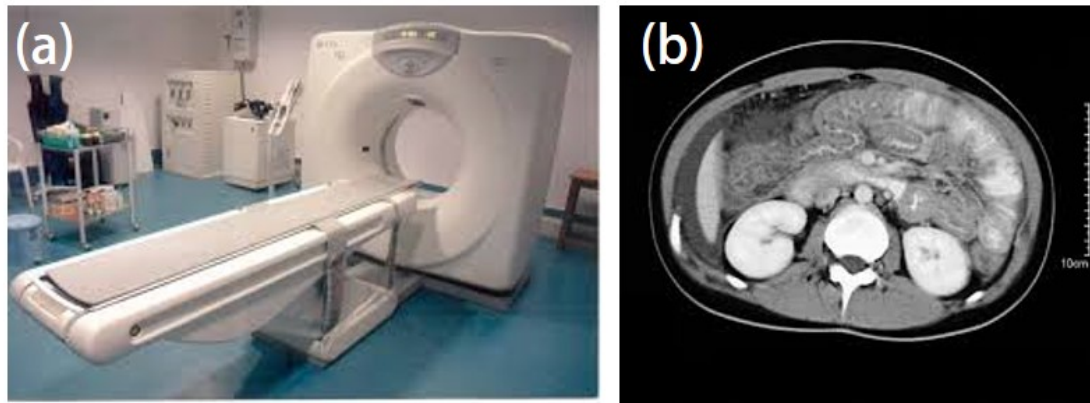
Computed Tomography: (a) outward appearance of CT; (b) CT image of eosinophilic gastroenteritis. [148]
